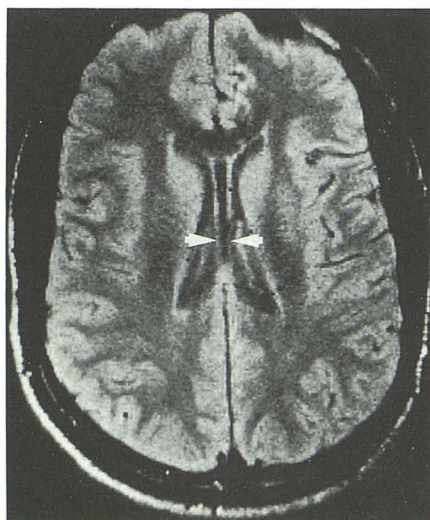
The cavum vergae on axial T2-weighted MR scan (spin-echo pulse sequence 2500/25/1). Twenty-one-year old male schizophrenic patient with a grade 3 cavum extending posteriorly into the cavum vergae (*arrowheads*).
